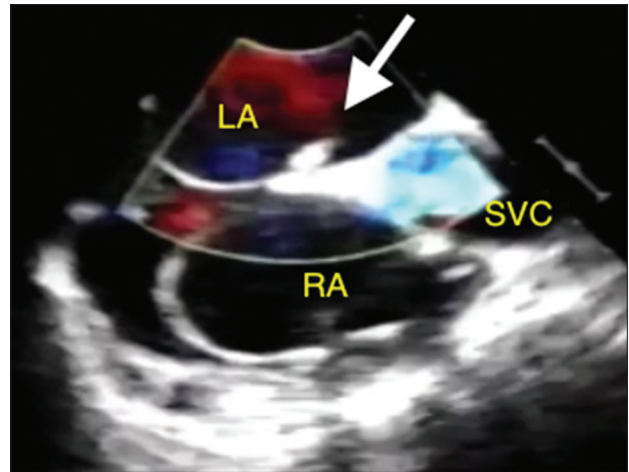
Transesophageal echocardiogram bi-caval view demonstrating the ventricular pacemaker lead (arrow) crossing into the left atrium through a patent foramen ovale. LA: Left atrium, RA: Right atrium, SVC: Superior vena cava
